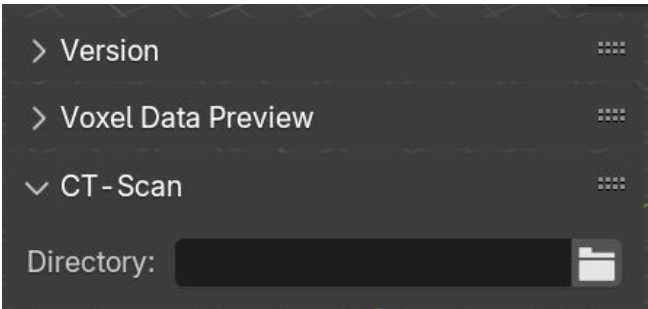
CT-Scan section.
